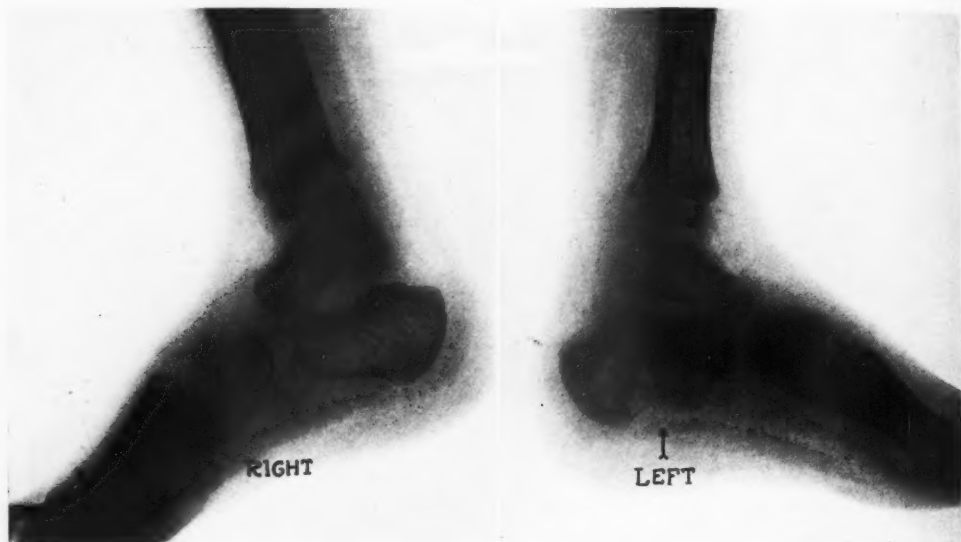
Roentgenogram showing chondroma of os calcis. Note the central rarefied area. Bone shell is intact. There are no trabeculations such as are so often seen in the giant-cell tumor and the healing bone cyst.
